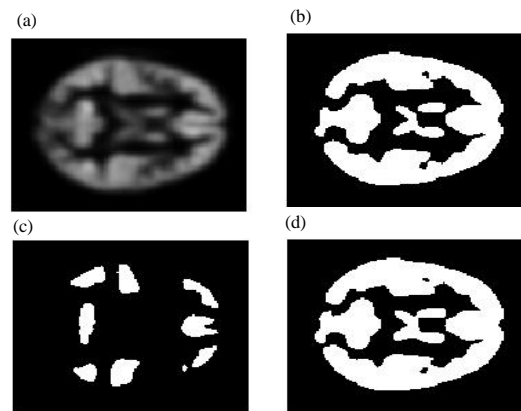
a) Normal brain MRI image without any thresholding technique applied; b) Otsu's method; c) Midpoint method and d) Hysteresis method
